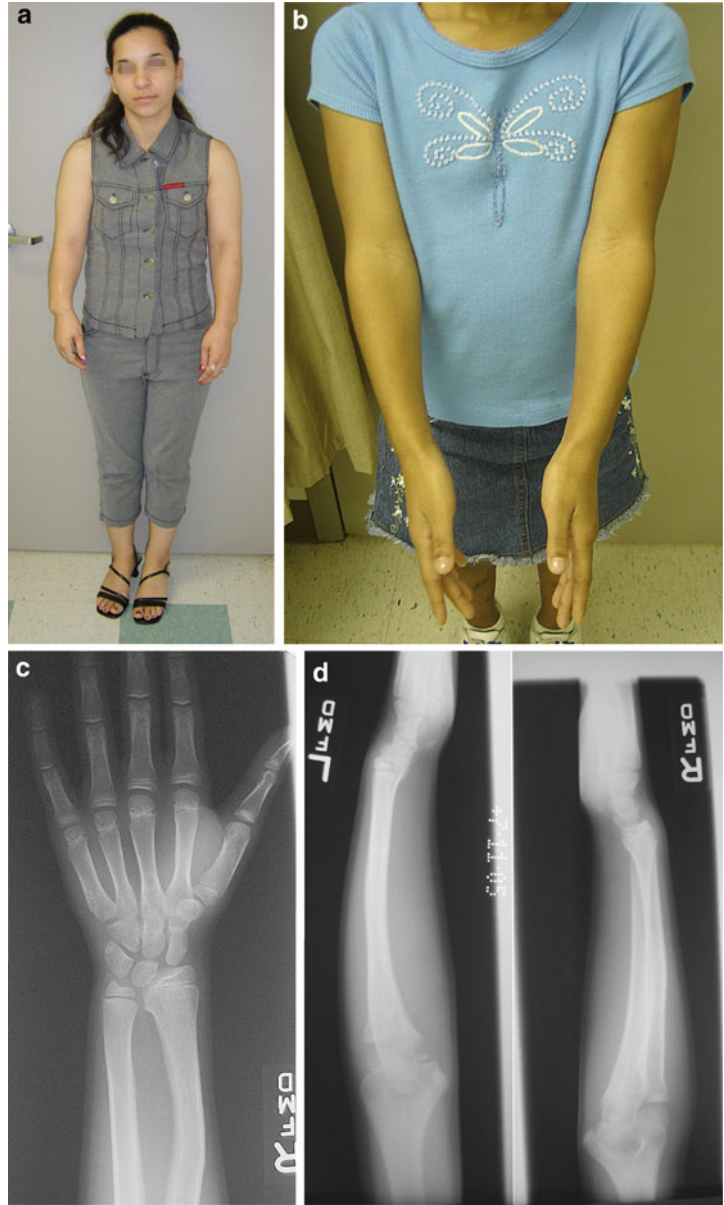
Mother and daughter with Leri-Weill syndrome with typical phenotype (a) and wrist radiographs (b, c)
